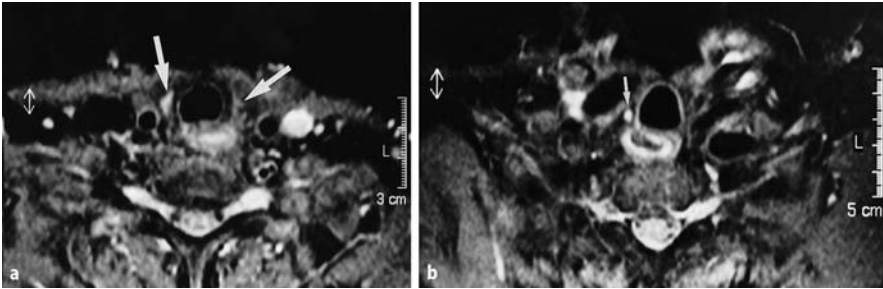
Thyroid remnants, transversal STIR images. a Typical appearance of thyroid remnants. This patient had had total thyroidectomy and twofold RIT for papillary thyroid cancer with the last therapeutic radioiodine scan negative. Follow-up sonography 4 months later showed equivocal tissue in the right thyroid bed. MRI proved thyroid remnants not only on the right but also on the left side (*arrows*). Note flow phenomenon (high signal) in the left internal jugular vein. b Demonstration of the MRI capabilities in delineating even minimal lesions: residual thyroid tissue of about 3 mm right to the trachea (*arrow*). Such small findings are hardly identified by sonography, particularly in this anatomical region (thoracic inlet). Without this STIR image, the lesion would have been much more difficult to identify on T1- and T2-weighted images
